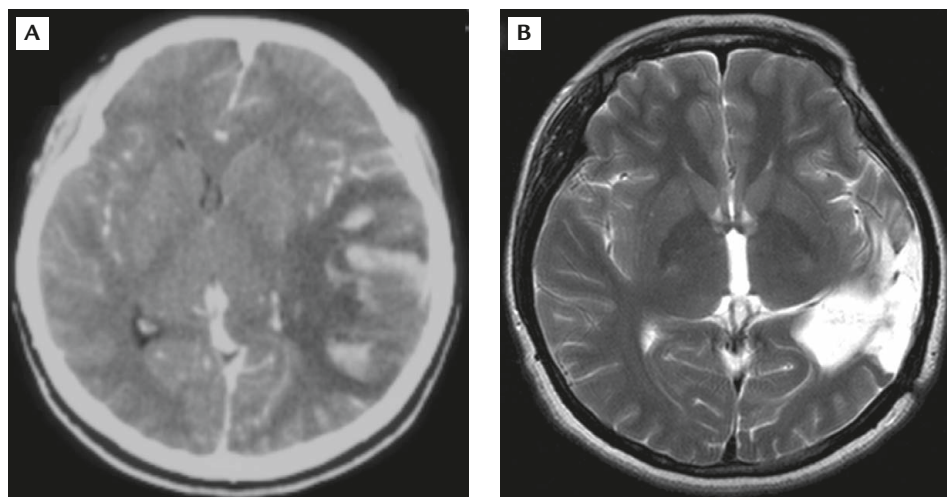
Cerebral venous thrombosis complicated with hemorrhagic transformation in a 29-year-old pregnant woman. (A) Computed tomography before craniotomy and (B) T2 weighted imaging after decompressive surgery show a significant reduction of compressive effect.
